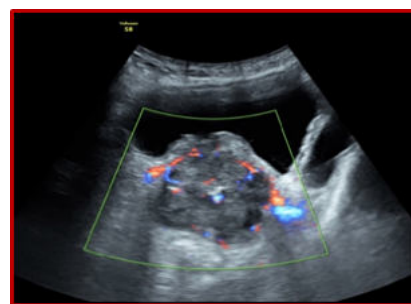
Same case as above with TRUS on Colour Doppler study
